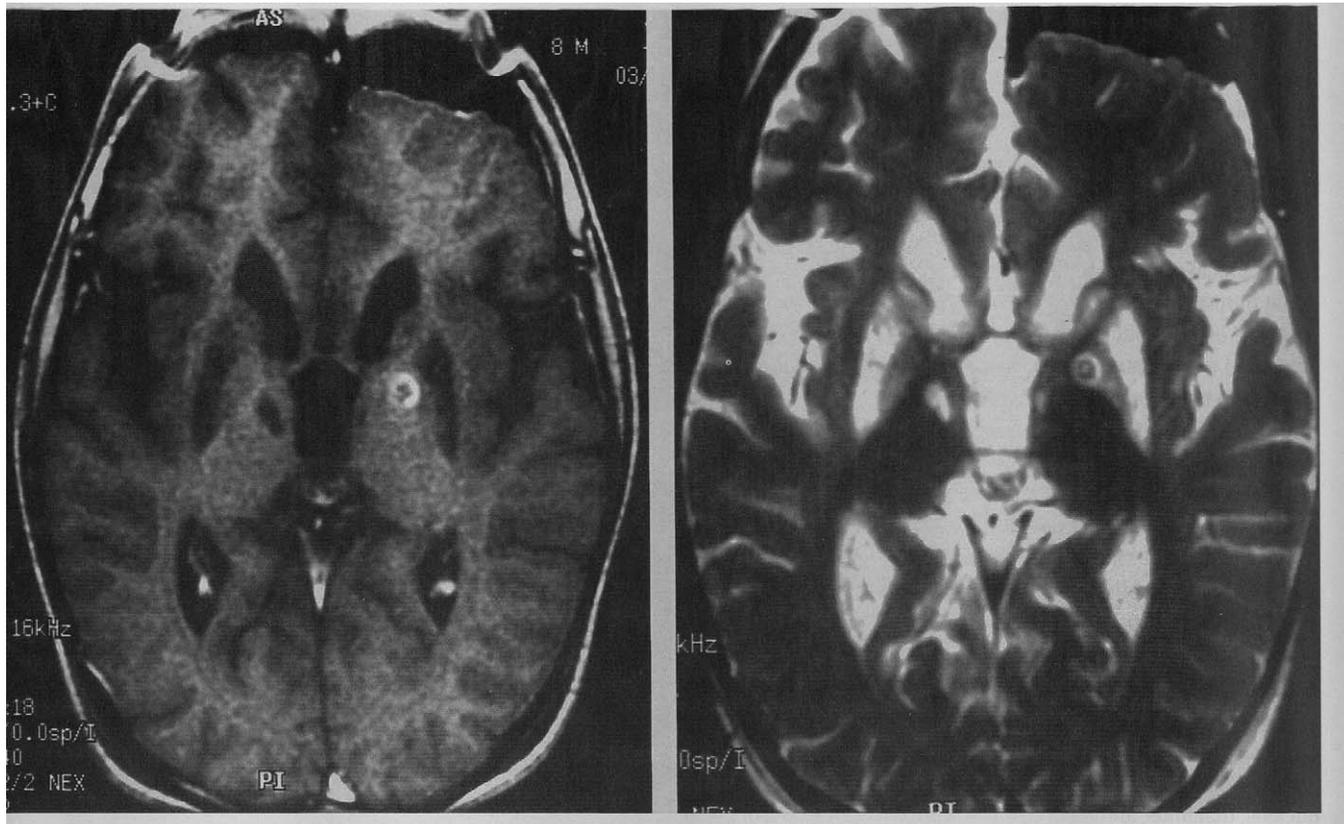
$T_1$ -weighted MRI after gadolinium infusion (*left*) and  $T_2$ -weighted MRI (*right*). Notice the complete destruction of the putamen and caudate seen as dark signal on  $T_1$ -weighted image and bright signal on  $T_2$ -weighted image. Also notice a large chronic lesion on the ventrolateral nucleus of the right thalamus and an acute radiofrequency lesion in the left globus pallidus internum showing a center of hypointensity and a rim of gadolinium enhancement. This lesion is seen on  $T_2$ -weighted image as a center of bright signal, surrounded by a dark signal that is encompassed by an area of bright signal corresponding to edema. The aspect of these lesions has been previously described.<sup>24</sup>
